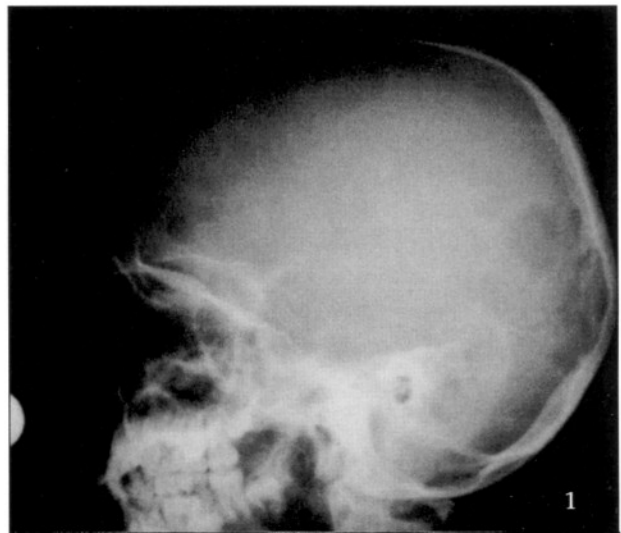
Plain x-rays, 1) lateral and 2) towne, reveal a right parietal, well circumscribed osteolytic lesion.
